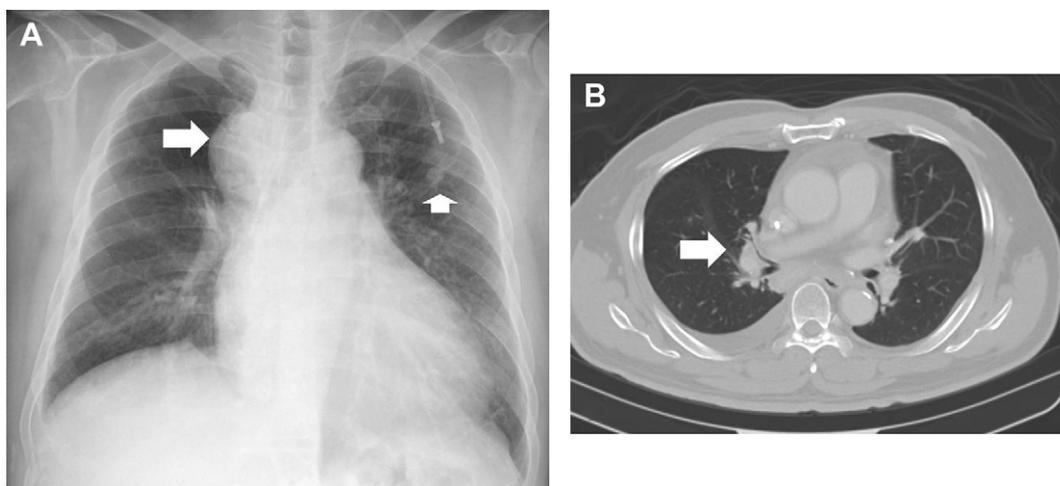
(A) Chest radiography showing a mass lesion (lung cancer, arrow) at the right paratracheal region, a calcified nodular lesion (arrow head) over the left upper lobe, increased infiltration over the bilateral lung, and pleural effusion in the right lung and (B) chest computed tomography demonstrating a new developed consolidation lesion with air bronchogram (arrow) over the right middle lobe and right pleural effusion in a patient with lung cancer who had coinfection with *Mycobacterium tuberculosis* and 2009 influenza A (H1N1) virus.
